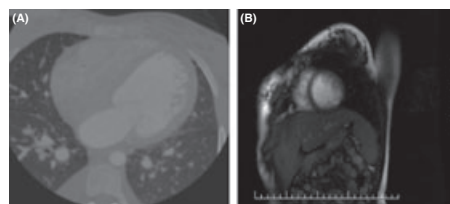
(A) Computed tomography (B) Magnetic resonance imaging showing increased trabeculation.
